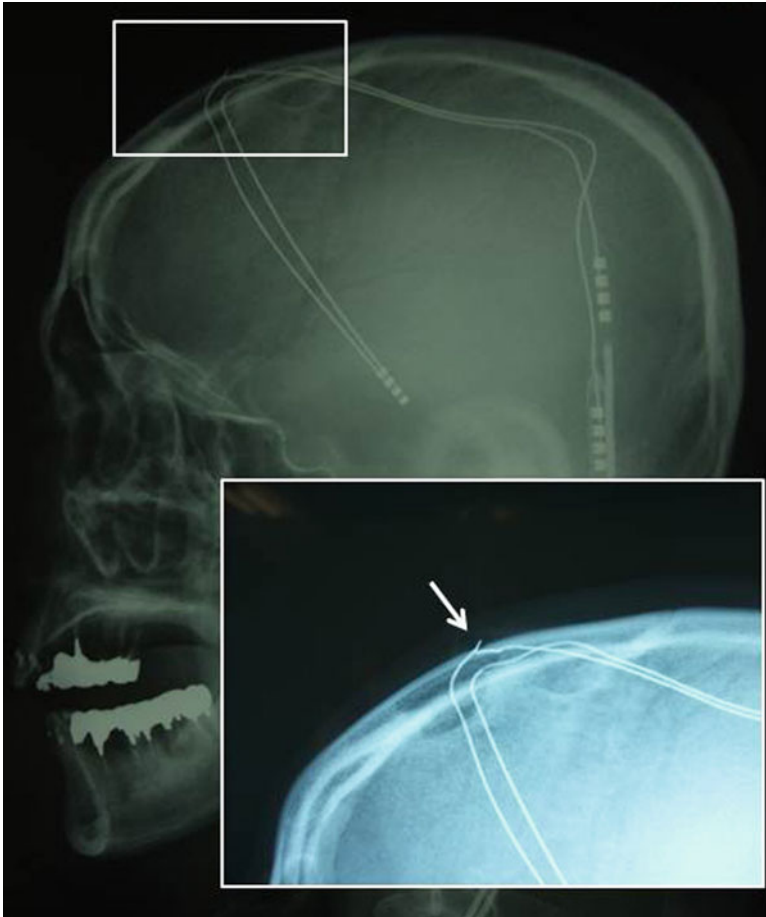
A plane skull X-ray film showing the lead fracture following head trauma. An arrow indicates the fractured lead
